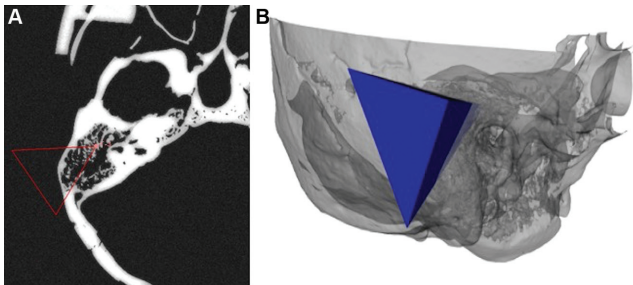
Representation of the allowable working space as seen on axial cut computed tomography (A) and 3-dimensional reconstruction (B) of the imaging.
